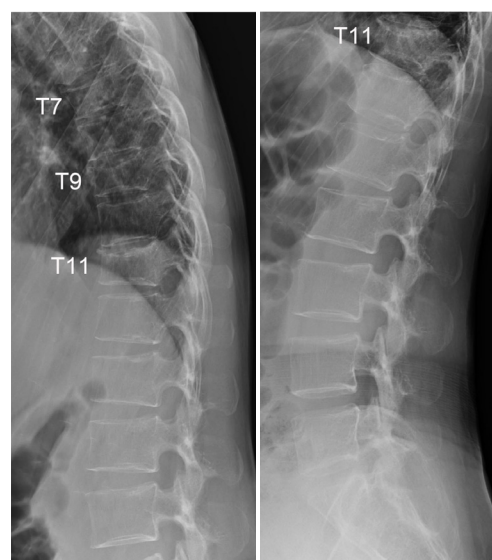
Plain radiographs of the thoracic and lumbar spine on the initial examination showing T7, T9, and T11 vertebral fractures.
